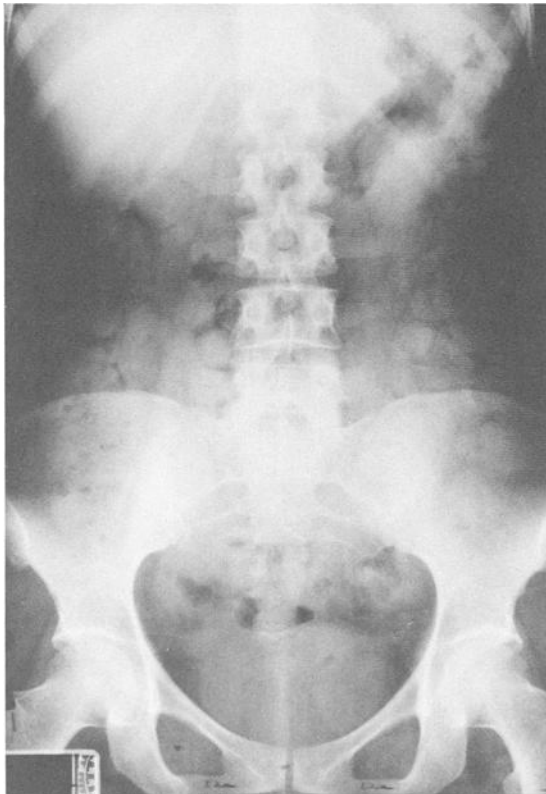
A plain film performed on admission shows obvious bags outlined by gas mainly in the left colon. The patient eventually eliminated 101 packages during the hospitalization.
